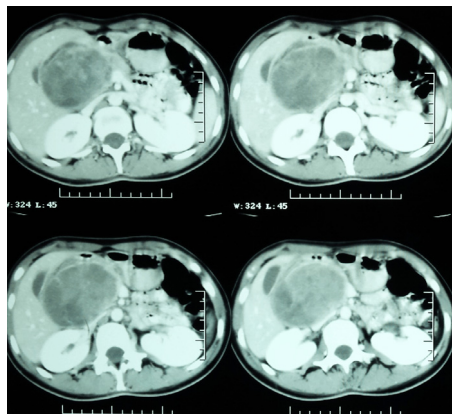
CT: heterogeneous, large mass, apparently developed from the liver. No images of local invasion or intra-abdominal metastases were found. Also, the CT examination did not reveal any dilatation of the hepatic or pancreatic ducts.
